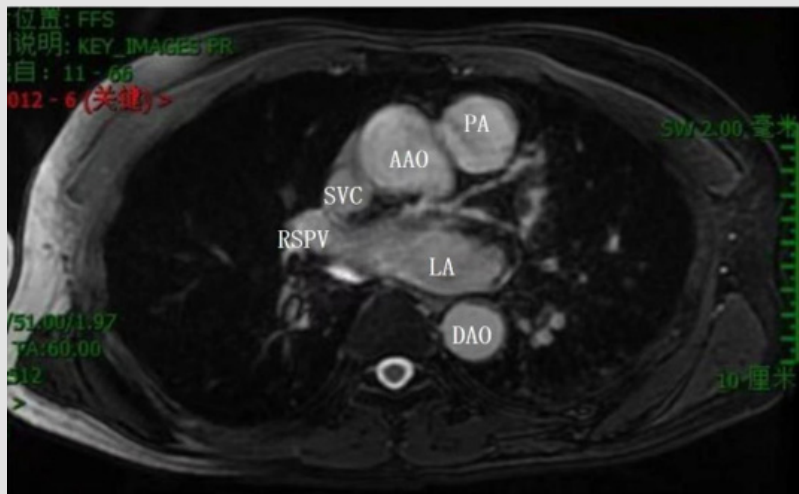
Cardiac magnetic resonance imaging (MRI) examination.
